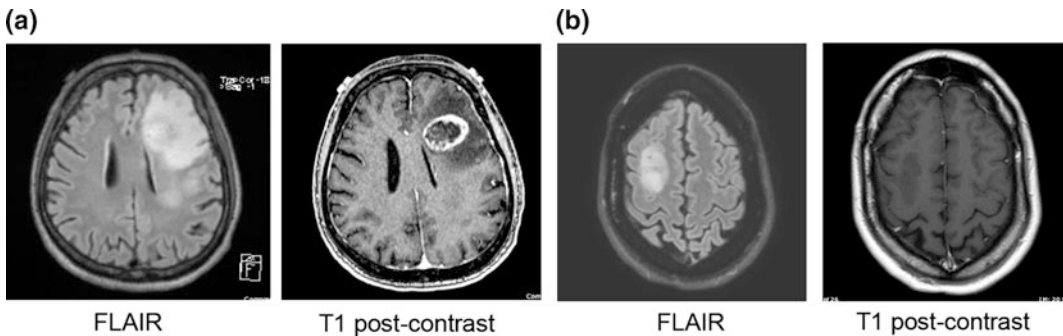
a Magnetic resonance imaging of brain—glioblastoma magnetic resonance imaging reveals the aggressive nature of glioblastoma with the typical ring enhancement, central necrosis, and significant mass effect. b Magnetic resonance imaging of brain—anaplastic
